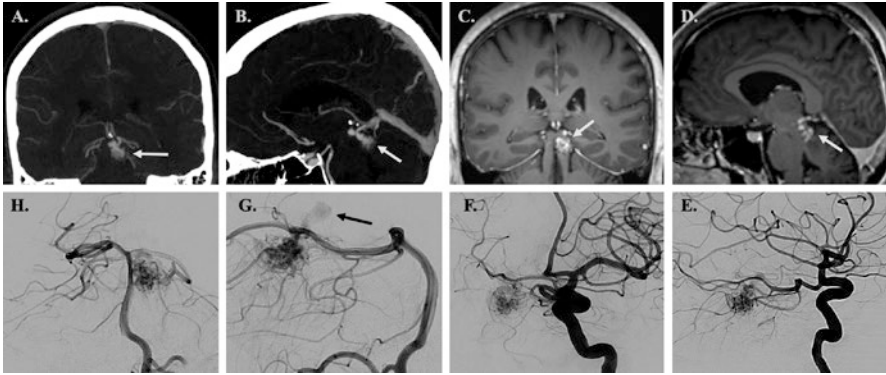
(a, b) Coronal and sagittal CTA MIP images depicting a small AVM (arrows) within the left midbrain. (c, d) Coronal and sagittal MPRAGE images again showcasing this small AVM (arrows). (e, f) Lateral and oblique DSA images show a large left fetal posterior communicating artery supplying blood from the anterior circulation to the AVM nidus. (g, h) Lateral and transfacial DSA images of a left vertebral artery injection demonstrate a small AVM nidus in the left midbrain that is supplied by left PCA branches. Early faint opacification of a dilated venous varix representing early venous drainage is appreciated (black arrow in image g)
